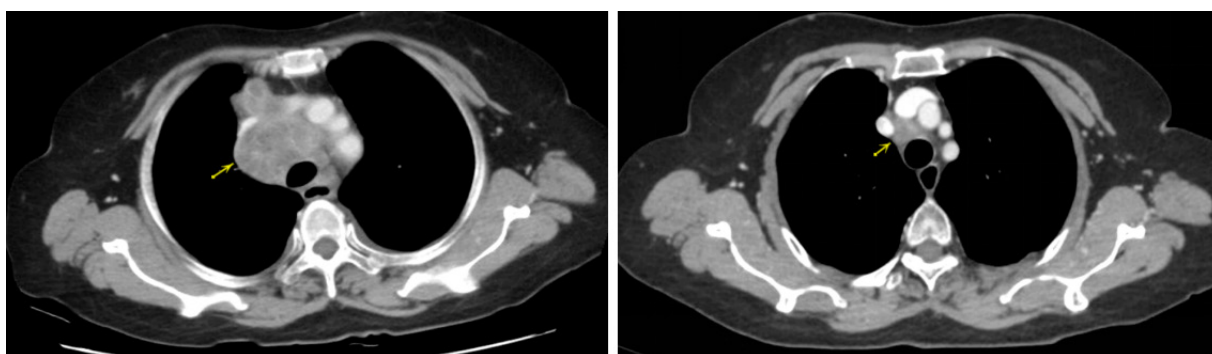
CT scan of the chest before and after Temozolomide treatment
